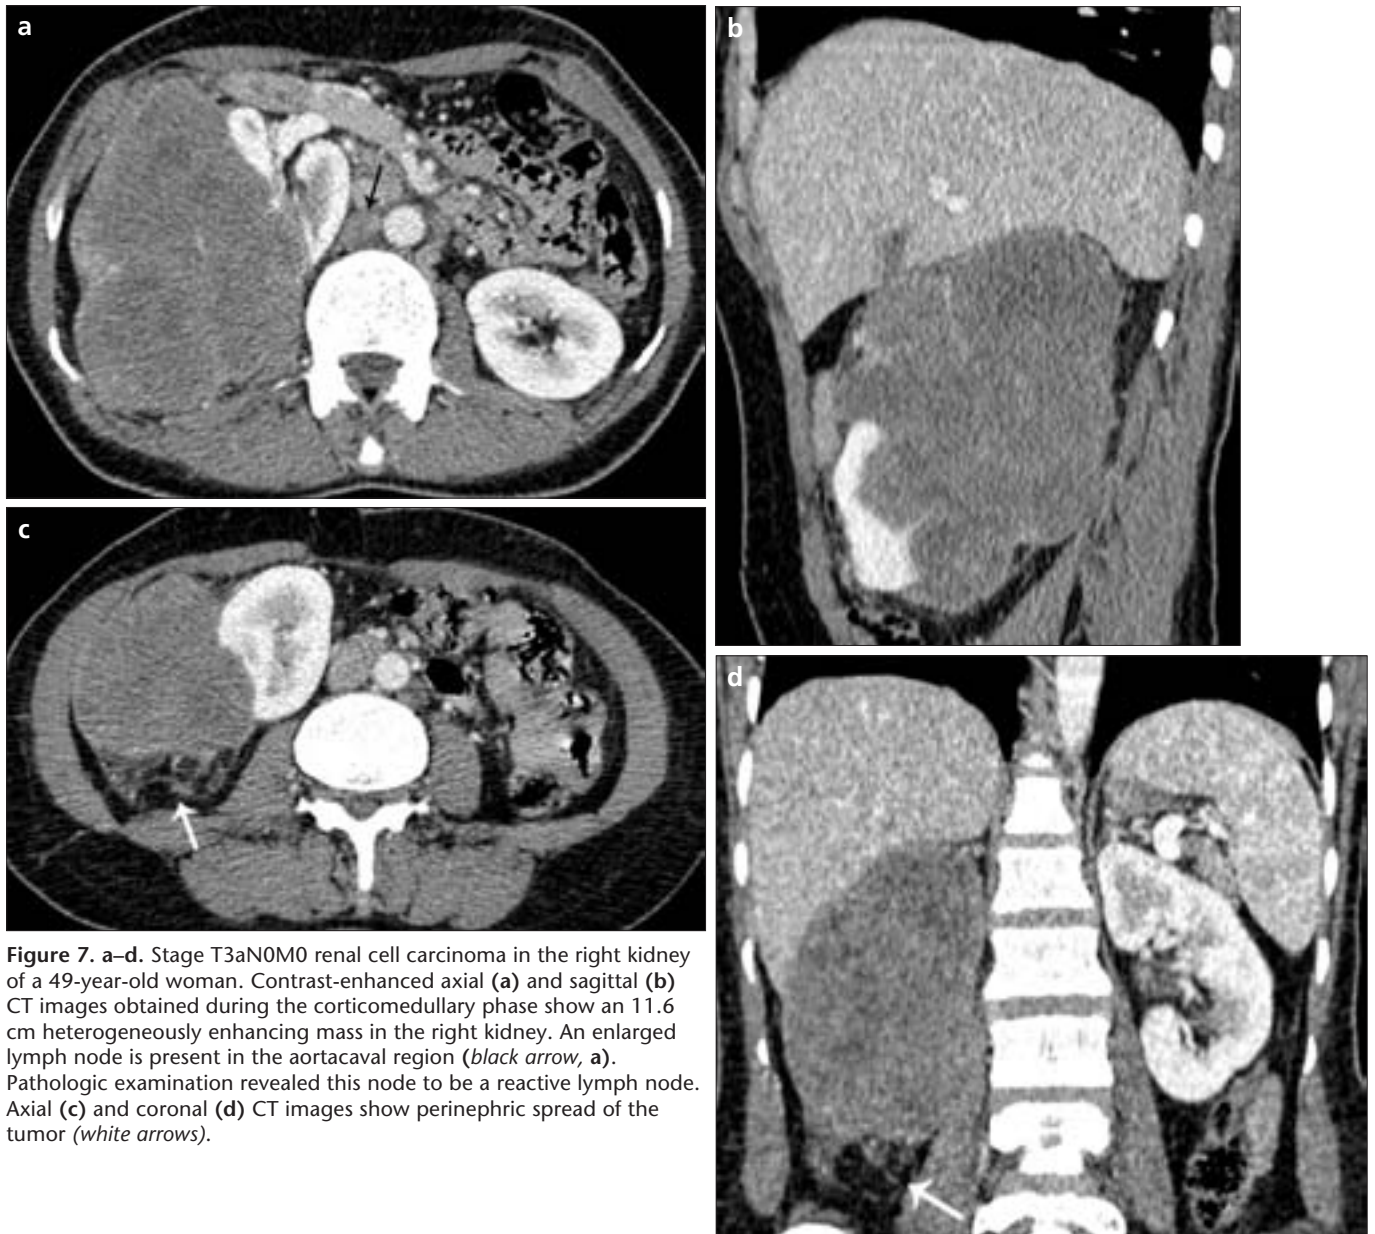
a–d. Stage T3aN0M0 renal cell carcinoma in the right kidney of a 49-year-old woman. Contrast-enhanced axial (a) and sagittal (b) CT images obtained during the corticomedullary phase show an 11.6 cm heterogeneously enhancing mass in the right kidney. An enlarged lymph node is present in the aortacaval region (black arrow, a). Pathologic examination revealed this node to be a reactive lymph node. Axial (c) and coronal (d) CT images show perinephric spread of the tumor (white arrows).
